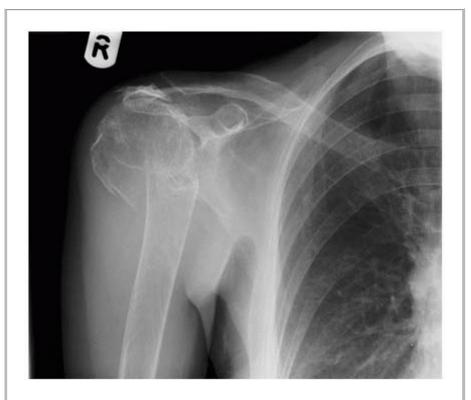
Radiograph showing fractured neck of humerus on the right.
